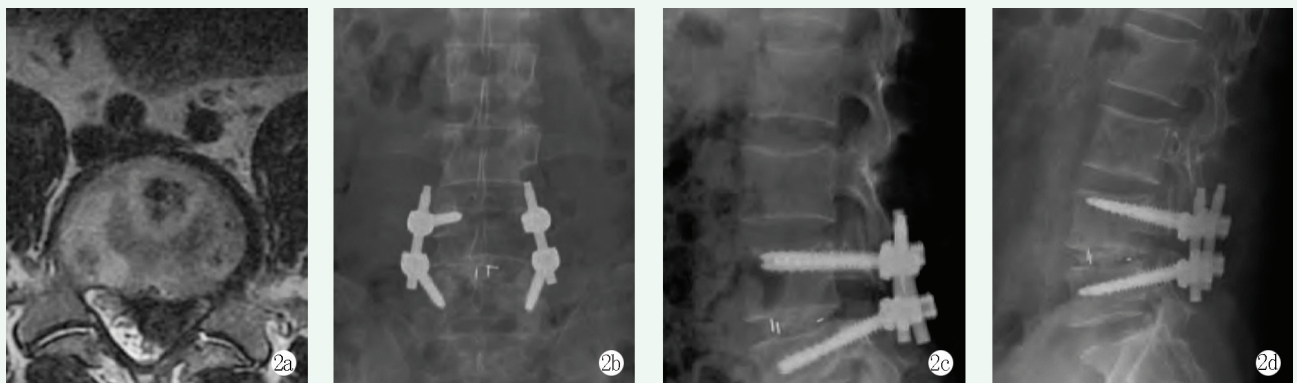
患者女性, 52 岁, 反复腰痛 3 年, 伴左下肢放射痛 3 个月余, 诊断为 $L_{4/5}$ 椎间盘突出症, 行双侧椎弓根钉棒内固定 PLIF。2a: 术前腰椎 MRI 显示 $L_{4/5}$ 椎间盘突出症; 2b~2d: 术后腰椎正侧位 X 线片显示融合器及椎弓根钉棒位置可接受。
